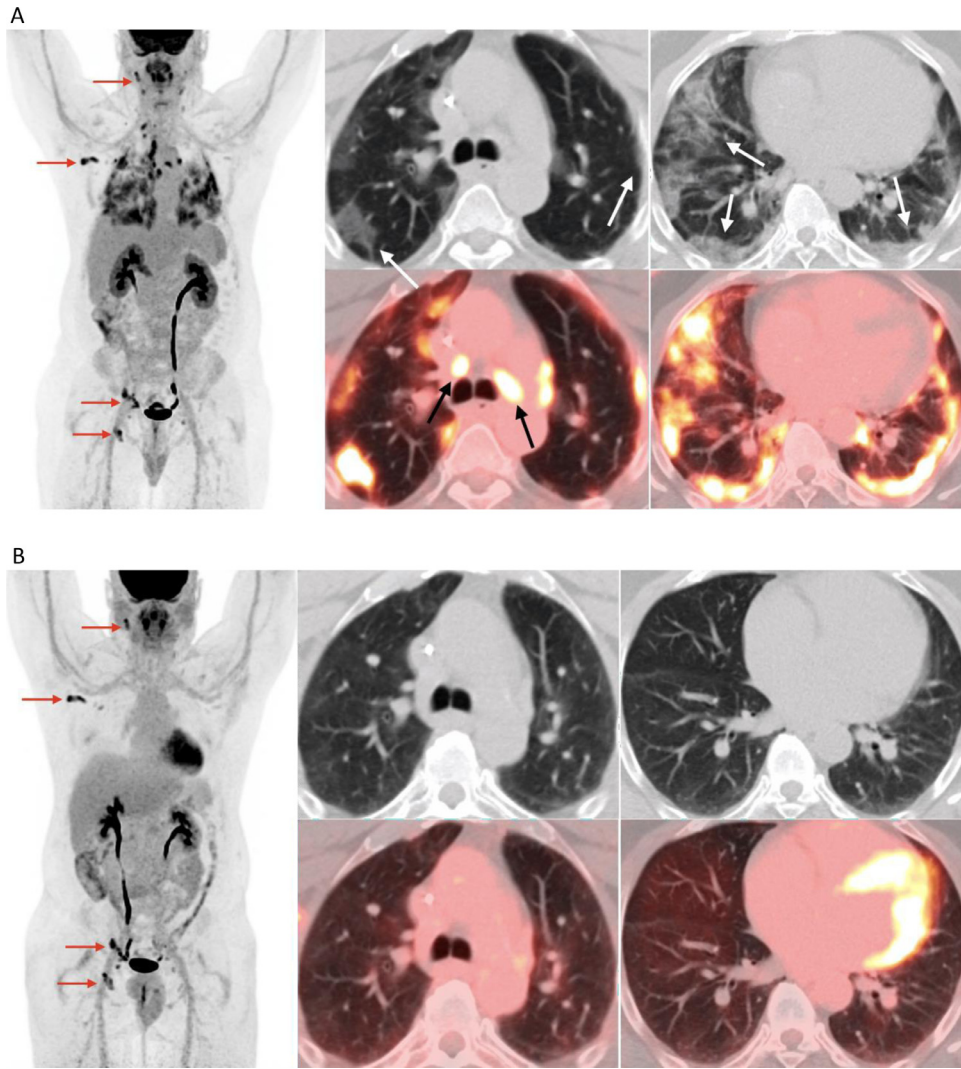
56-year-old male with Hodgkin's lymphoma presents for follow-up PET/CT complaining of neck discomfort. (Panel A) MIP image shows uptake in bilateral lungs and mediastinum and bilateral neck, right axilla, right pelvis, and inguinal regions (red arrows). Axial PET/CT shows bilateral ground-glass opacities in the upper lobes and patchy consolidations in the lower lobes (white arrows) with associated mediastinal lymphadenopathy (black arrows). (Panel B) PET/CT obtained four months after shows residual ground-glass opacities and resolution of mediastinal lymphadenopathy. MIP images show persistent cervical and right axillary, pelvic, and inguinal lymphadenopathy (red arrows) related to lymphoma.
